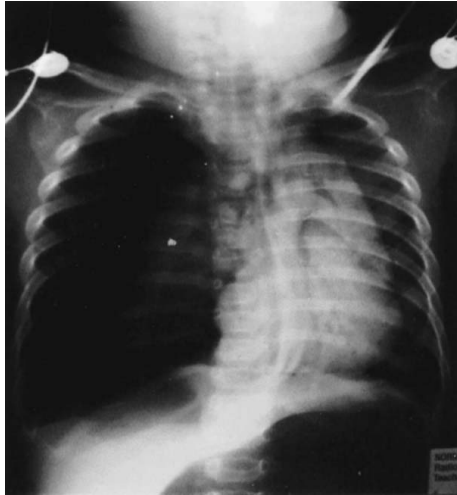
Congenital lobar emphysema. The radiographic appearance may be confused with tension pneumothorax or decreased lung volume (e.g., atelectasis) on the contralateral side.
